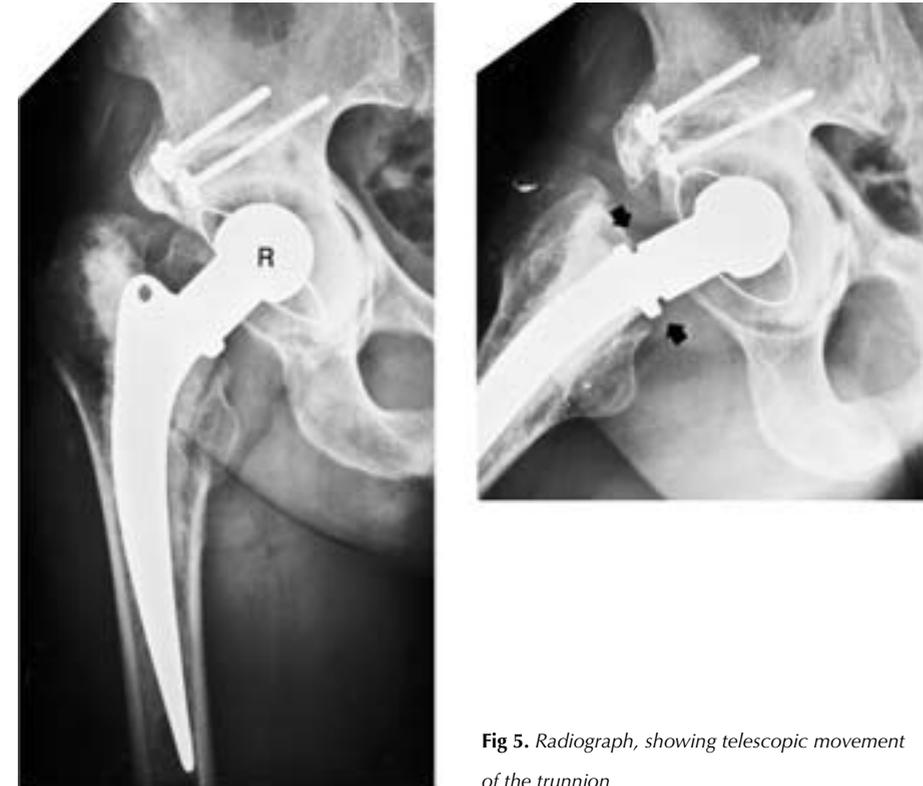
Radiograph, showing telescopic movement of the trunnion
